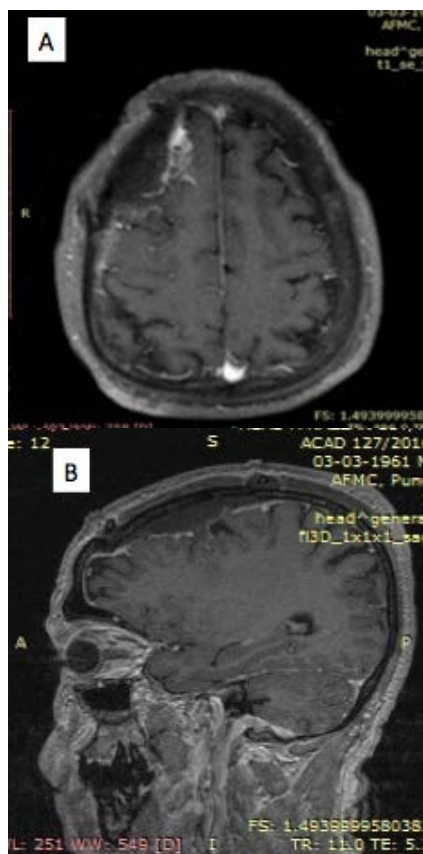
Post operative contrast MRI A(axial) & B (sagittal)– showing complete excision of the tumor
